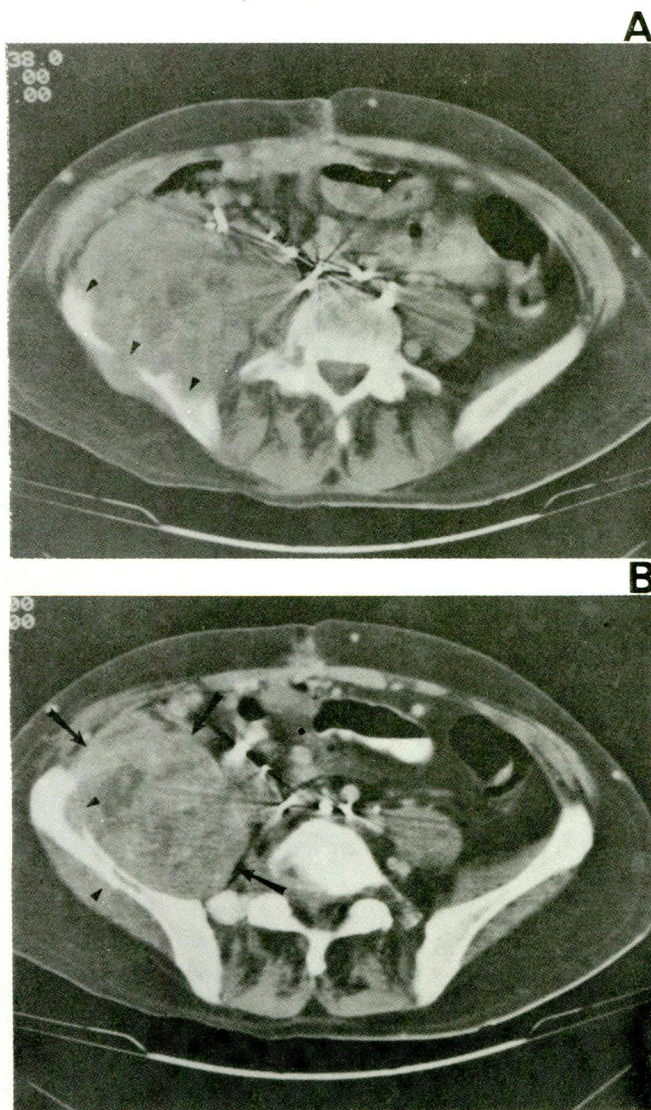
Embryonal carcinoma of the testicle with extranodal metastasis to the muscle and bone. History of previous pelvic node dissection. CT scans at the level of the iliac crest (A) and iliac wing (B) show a large mass involving the ilio-psoas muscle (arrows) and destroying the iliac bone (arrowheads).
